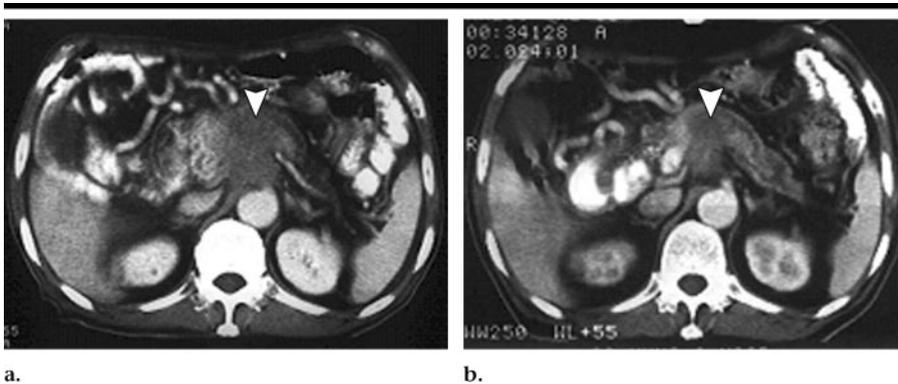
(a, b) Transverse contrast-enhanced conventional CT scans obtained (a) 1 month before and (b) 9 months after high-intensity focused ultrasound ablation for advanced, unresectable pancreatic cancer (arrowhead) in 78-year-old man. The lesion was 7.5 × 6.5 × 6.0 cm in diameter and located in the head and the body of the pancreas. There was an obvious regression in lesion size after high-intensity focused ultrasound.
